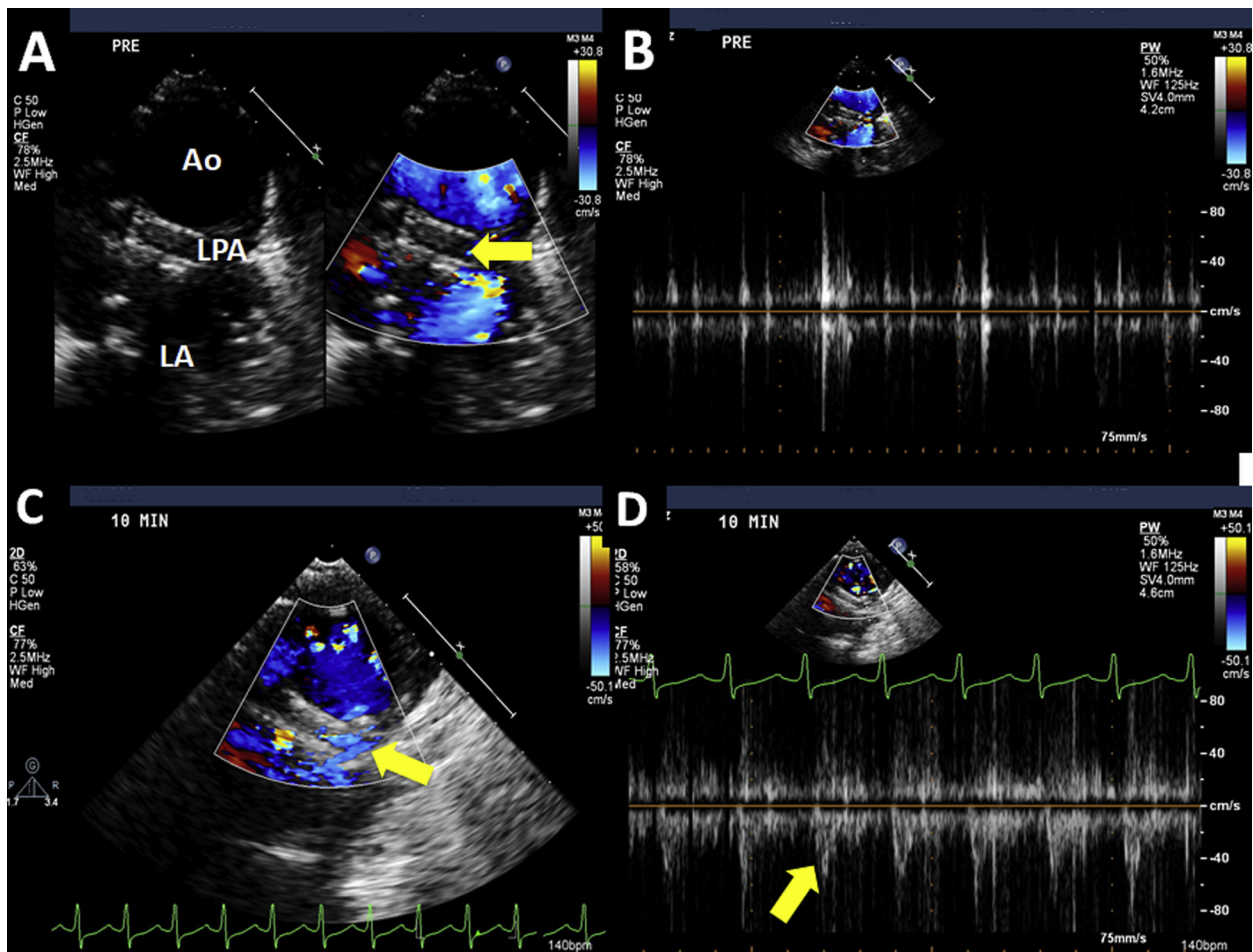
Two-dimensional and color Doppler images demonstrating absence of flow in the left pulmonary artery, where the stent was placed (A). Pulsed-wave Doppler confirming absence of signal with the sample volume placed in the left main pulmonary artery (B). At 50 min of sonothrombolysis, two-dimensional color flow (C) and Doppler (D) signs of left pulmonary artery recanalization are observed (yellow arrows). Ao, Aortic arch; LA, left atrium; LAP, left pulmonary artery branch.
